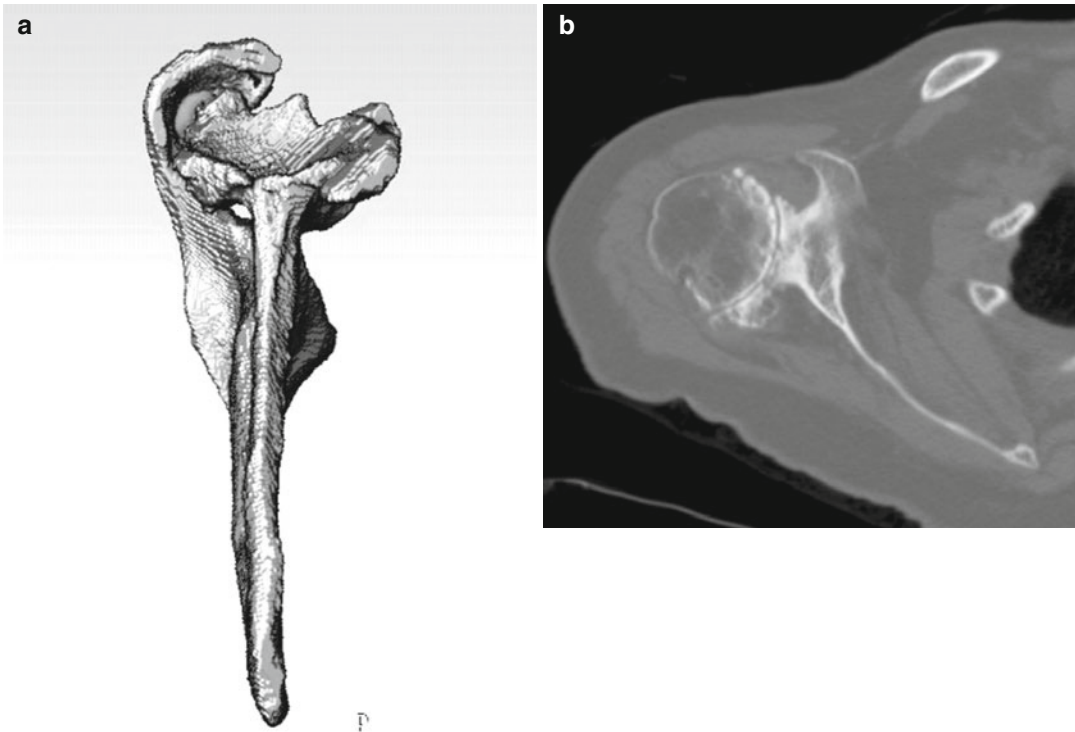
3D CT reconstructions (a) are more reliable than 2D CT reconstructions (b) in estimating the true glenoid version
